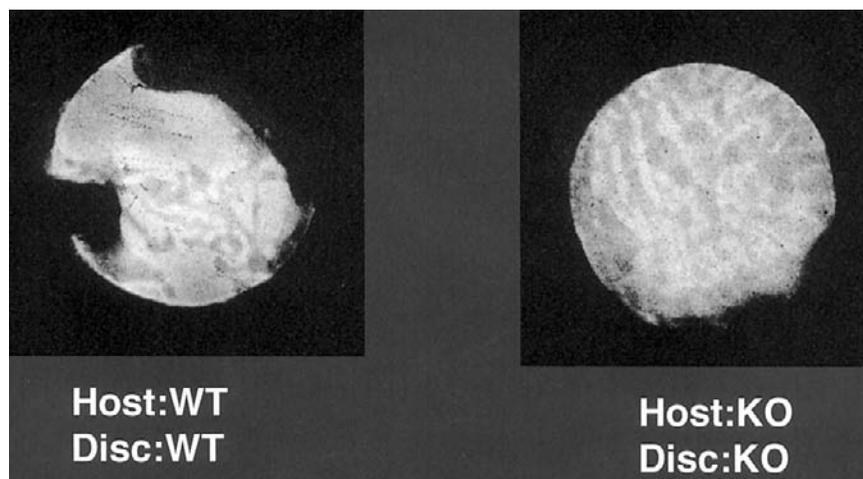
OPN is required for ectopic bone resorption. Bone discs derived from the calvaria were implanted intramuscularly as described by Asou *et al.* (2001). Four weeks after implantation, the discs were removed and examined using soft X-rays.
